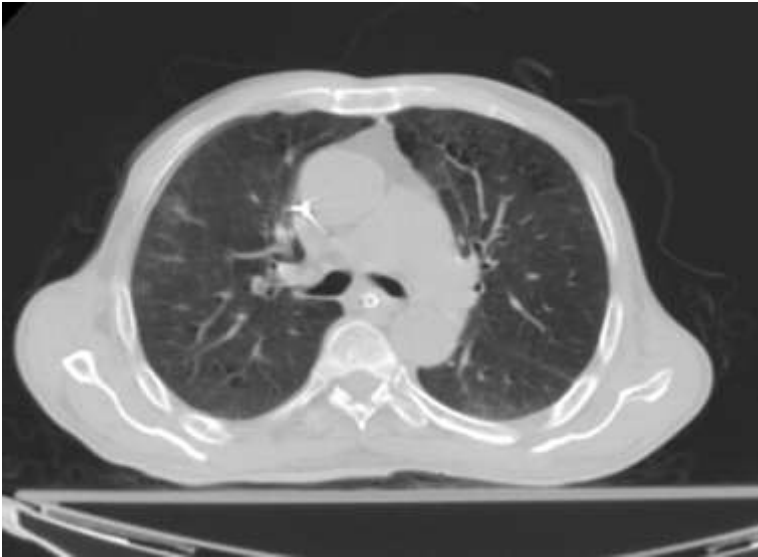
CT image showing pulmonary window of bilateral multi-focal ground glass densities seen at both lung fields and bilateral mild pleural (4a), CT image showing pulmonary window of Bilateral multi-focal ground glass densities seen at right lung fields (4b)
